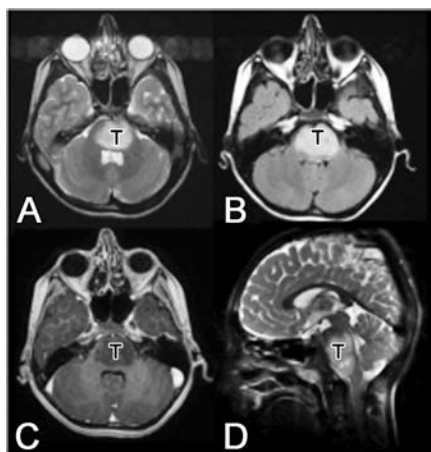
Diffuse pontine glioma (T) showing A) Axial T2 weighted MRI showing a diffusely hyperintense signal in the pons. B) Axial flair image at the same cut showing the somewhat more pronounced representation of the same hyperintense area in the pons. C) T1 weighted axial MRI with contrast at the same level showing a heterogeneously hypointense area of the pons with almost no contrast enhancement seen. D) T2 weighted sagittal cuts showing the diffuse pontine glioma occupying most of the pons.
